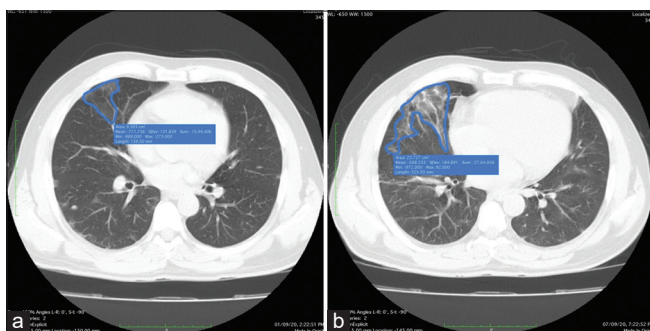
Initial (a) and follow-up (b) high-resolution computed tomography axial images of middle aged male patient; showing progressive change from a patch of ground-glass opacity to consolidation with increase in the cross-sectional area along with its density (HU)
